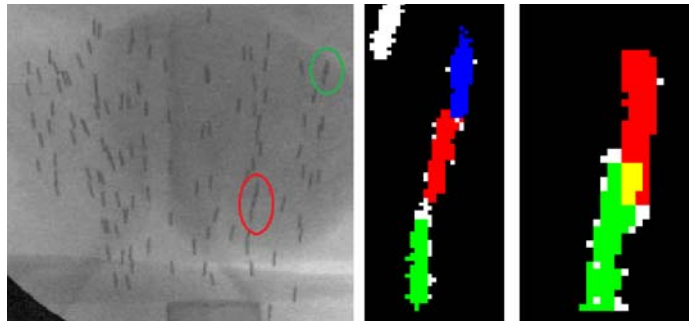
Clinical example showing successful declustering in two- and three-seed clusters. (Left) the input X-ray image on the left is displayed, in red the three seed cluster is highlighted, in green the two-seed cluster. (Right) the detection of the seeds belonging to the three- and two- seed clusters respectively.
